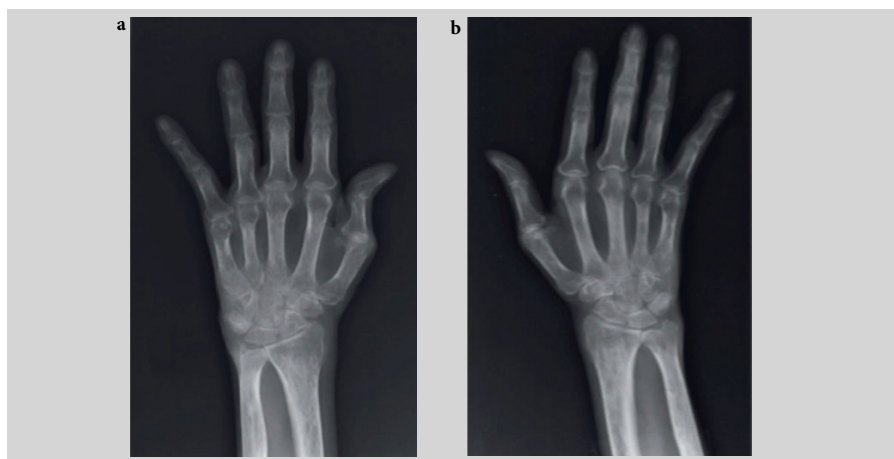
Posteroanterior radiograph of hands demonstrate erosive disease at bilateral ulnar styloids. Diffuse inflammatory joint space narrowing of the metacarpophalangeal (MCP) joints is present: (a) greater than (b). As the rheumatoid process becomes more established and destructive, one sees the subsequent ulnar deviation of the fingers at the MCP joints, as well as the radial deviation at the wrist. The reason for this has not been clearly established – perhaps the ulnar drift of the fingers is a mechanical compensation for the radial deviation at the wrist. The bones of this patient are clearly less mineralized and one does see the beginnings of a Boutonnière deformity of the thumb in the left hand.
